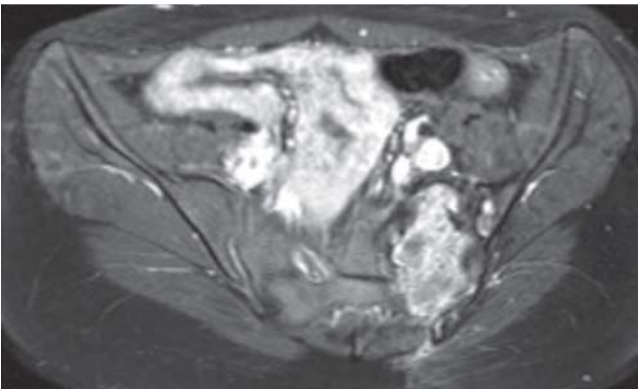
Axial MRI scan (T1 TSE FS with contrast medium) 18 months after embolisation. A shrinking of the ABC to $3.0 \times 5.4 \times 5.0$ cm can be detected. Further a reduction of cystic areas and fluid levels can be detected.
